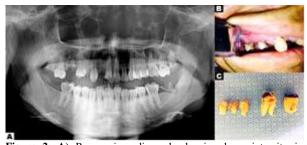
A) Panoramic radiograph showing bone integrity in structures of the middle third and mandible. B) Intraoral aspect. C) Dental elements extracted by association with carious lesions.
